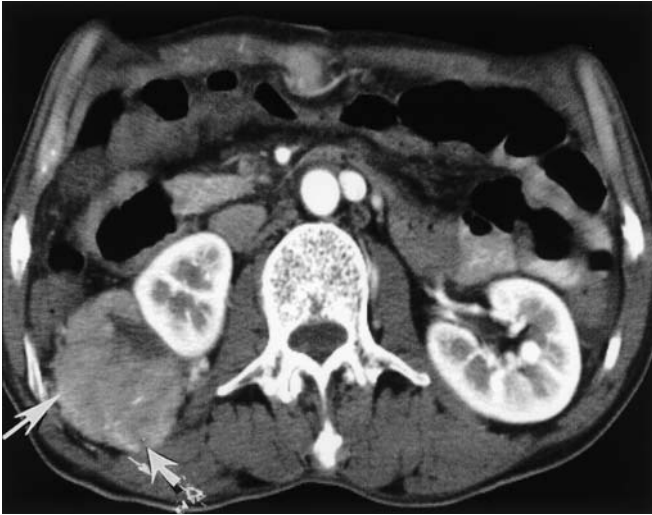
Retroperitoneal metastasis. The CT scan shows anteromedial displacement of the right kidney due to a lobulated-contour, hypervascular mass (*arrows*) in the pararenal space
